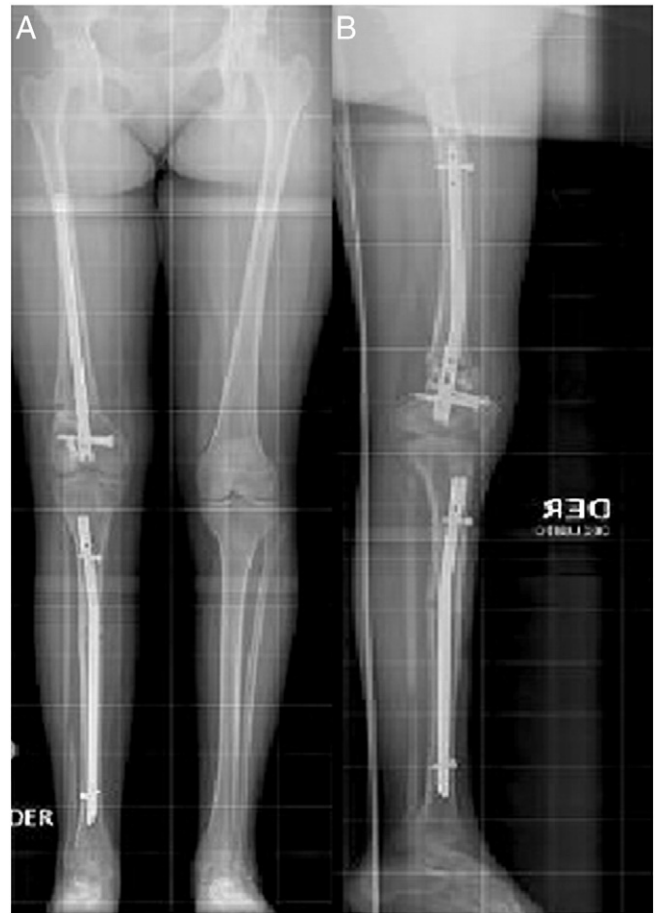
Full-length postoperative radiographs demonstrate angular deformity correction in both AP (A) and lateral (B) projections.
